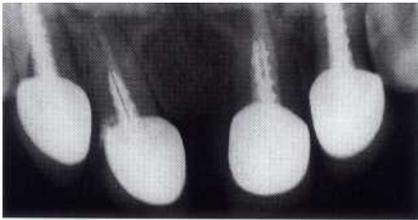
Radiograph of the patient shown in Fig. 17-44 with nursing bottle syndrome whose teeth were restored with complete endodontics, preformed stress-relieving posts, and porcelain-fused-to-metal crowns.
